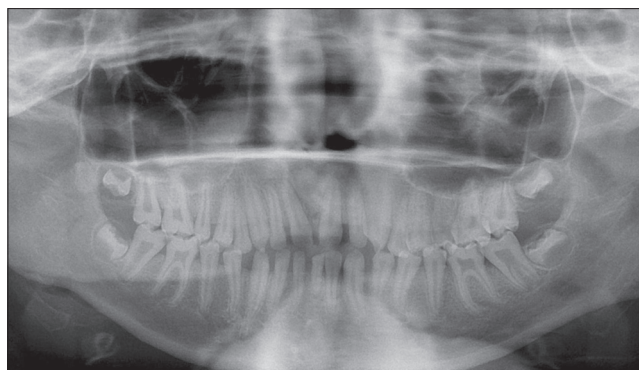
Panoramic radiograph of the 13-year-old sibling
